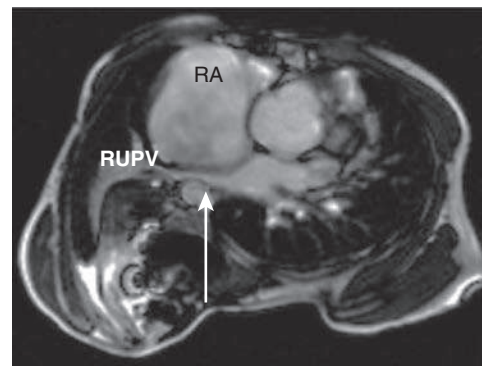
Compression of right upper pulmonary vein. Transverse magnetic resonance image of a patient with a modified classic Fontan for tricuspid atresia and severe rotoscoliosis. The arrow designates the site where the massively enlarged right atrium (RA) compresses the right upper pulmonary vein (RUPV). (From Khairy P, Poirier N, Mercier L-A. Univentricular heart. *Circulation*. 2007;115:800-812.)
